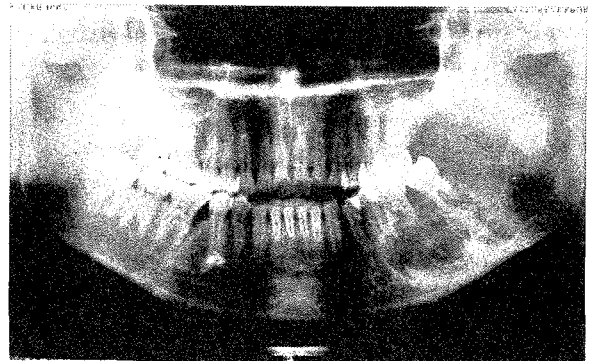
Preoperative panoramic radiograph showing multiloculated radiolucency from 35 to the left vertical ramus (Case 2).
